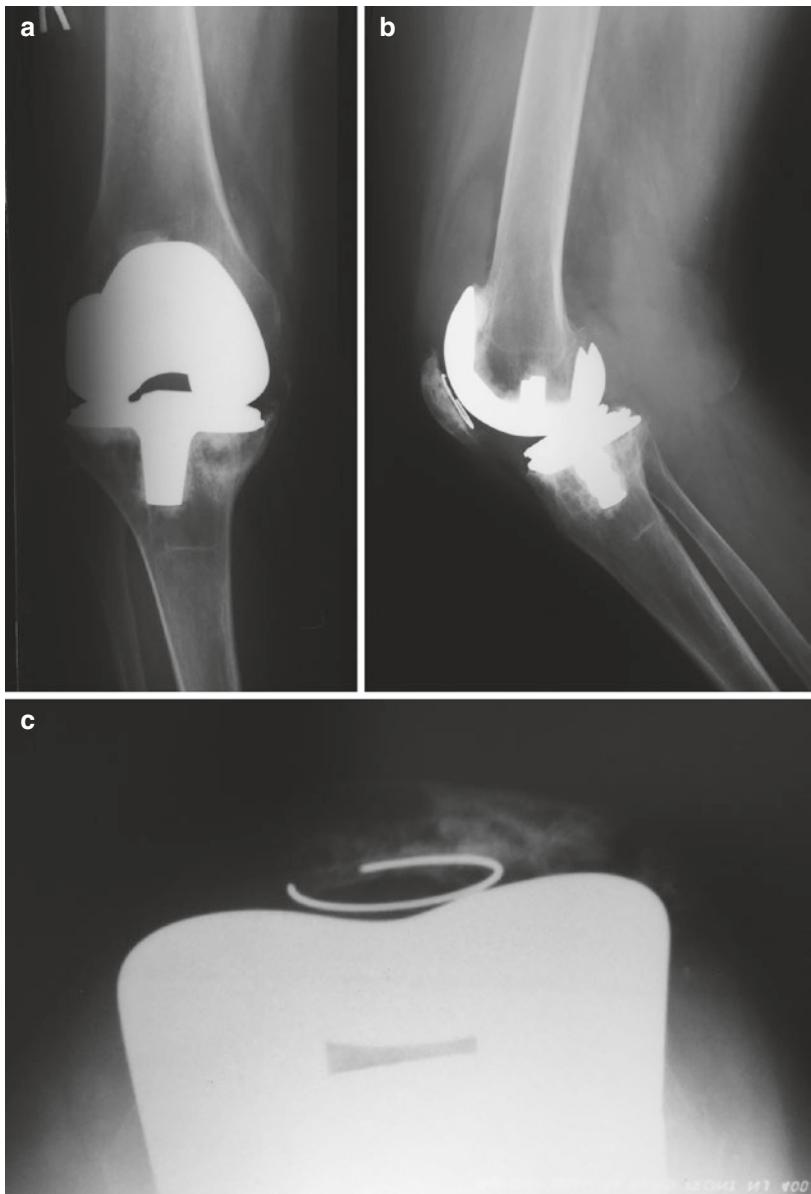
(a) Anteroposterior (AP), (b) lateral, and (c) Merchant patellar radiographs of a failed total knee replacement with tibial component subsidence, medial tibial osteolysis, and patellar component loosening
